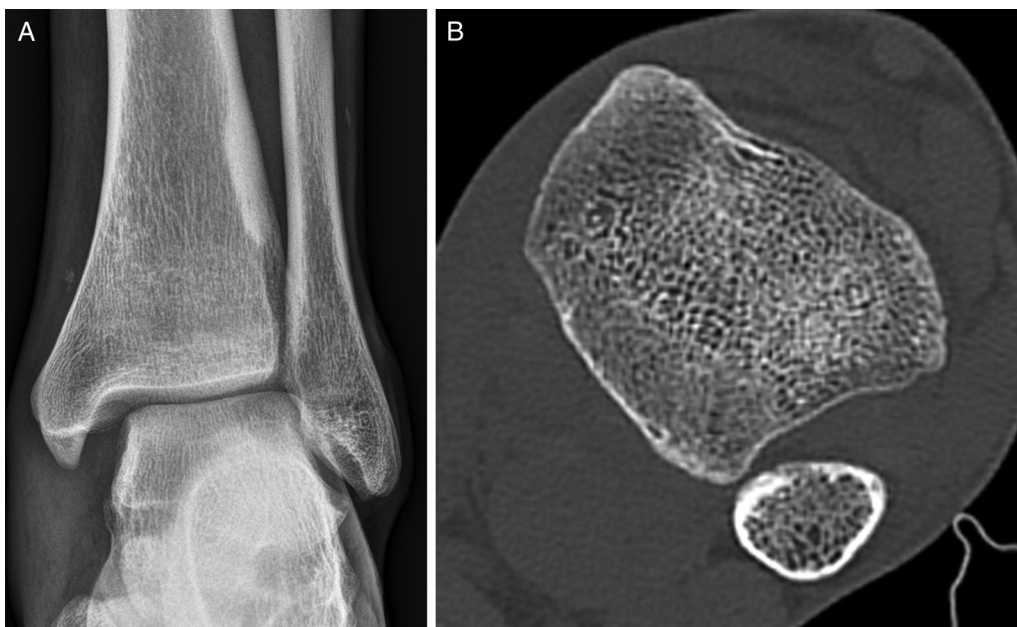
(A) Anteroposterior view and (B) view of horizontal computed tomography scan of the distal syndesmosis lesion.
